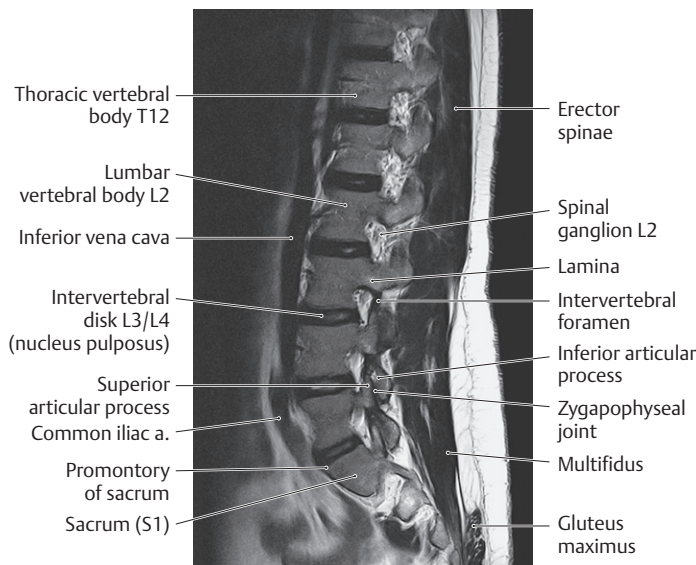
MRI of the lumbar spine
